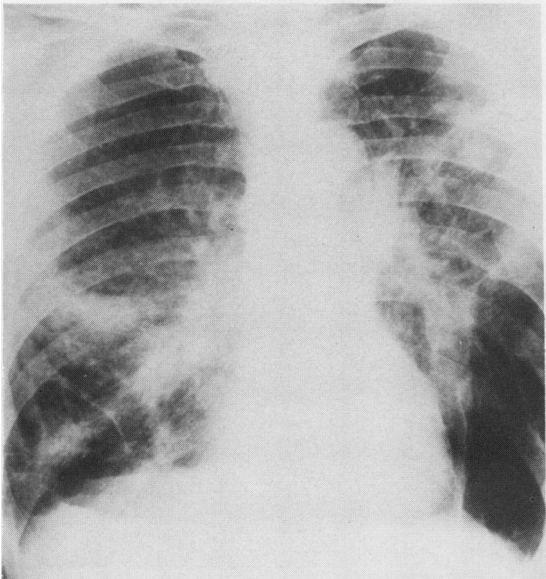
Posteroanterior radiograph of patient 4 showing bilateral progressive massive fibrosis and bullous emphysema.
